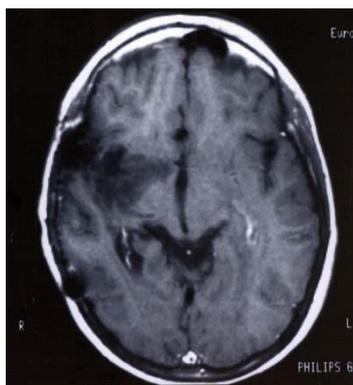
Michael, post-operative MRI showing extensive right frontotemporal cortical damage
